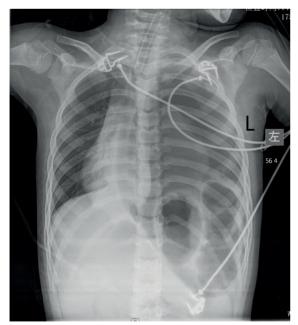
Initial chest X-ray in supine position showing the left lung field is hyperlucent with a rightward mediastinal shift.
